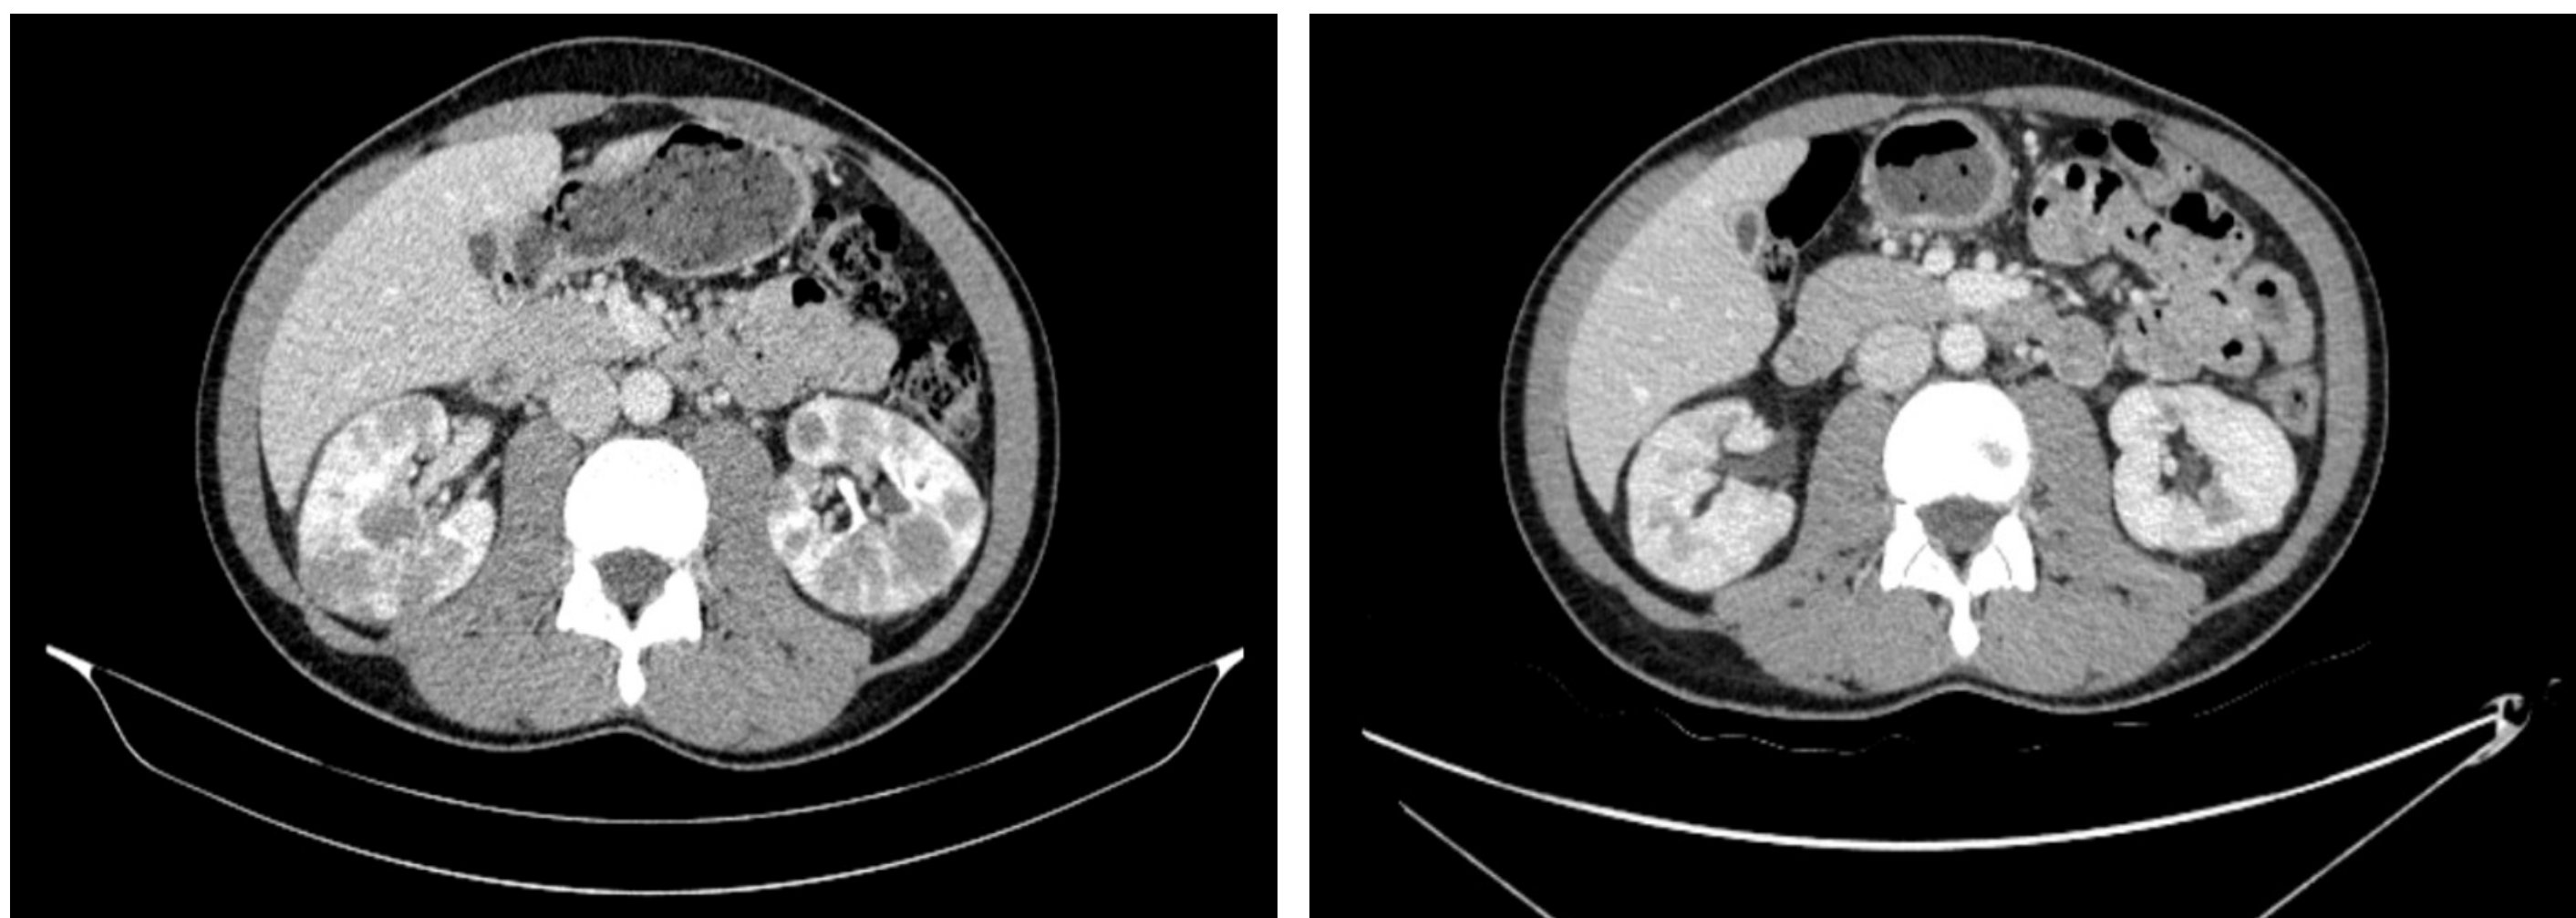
Abdominal CT scan at initial presentation (July 2023) demonstrating bilateral nephromegaly with multiple hypodense lesions (left image). Abdominal CT scan prior to allogeneic stem cell transplantation (August 2024) with no evidence of active disease (right image).
